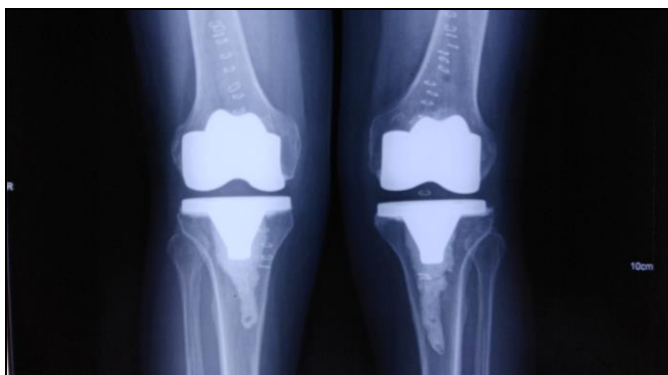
Post Operative X-Ray Bilateral Knee: Bilateral Total Knee Replacement (High Flexion Knee)
